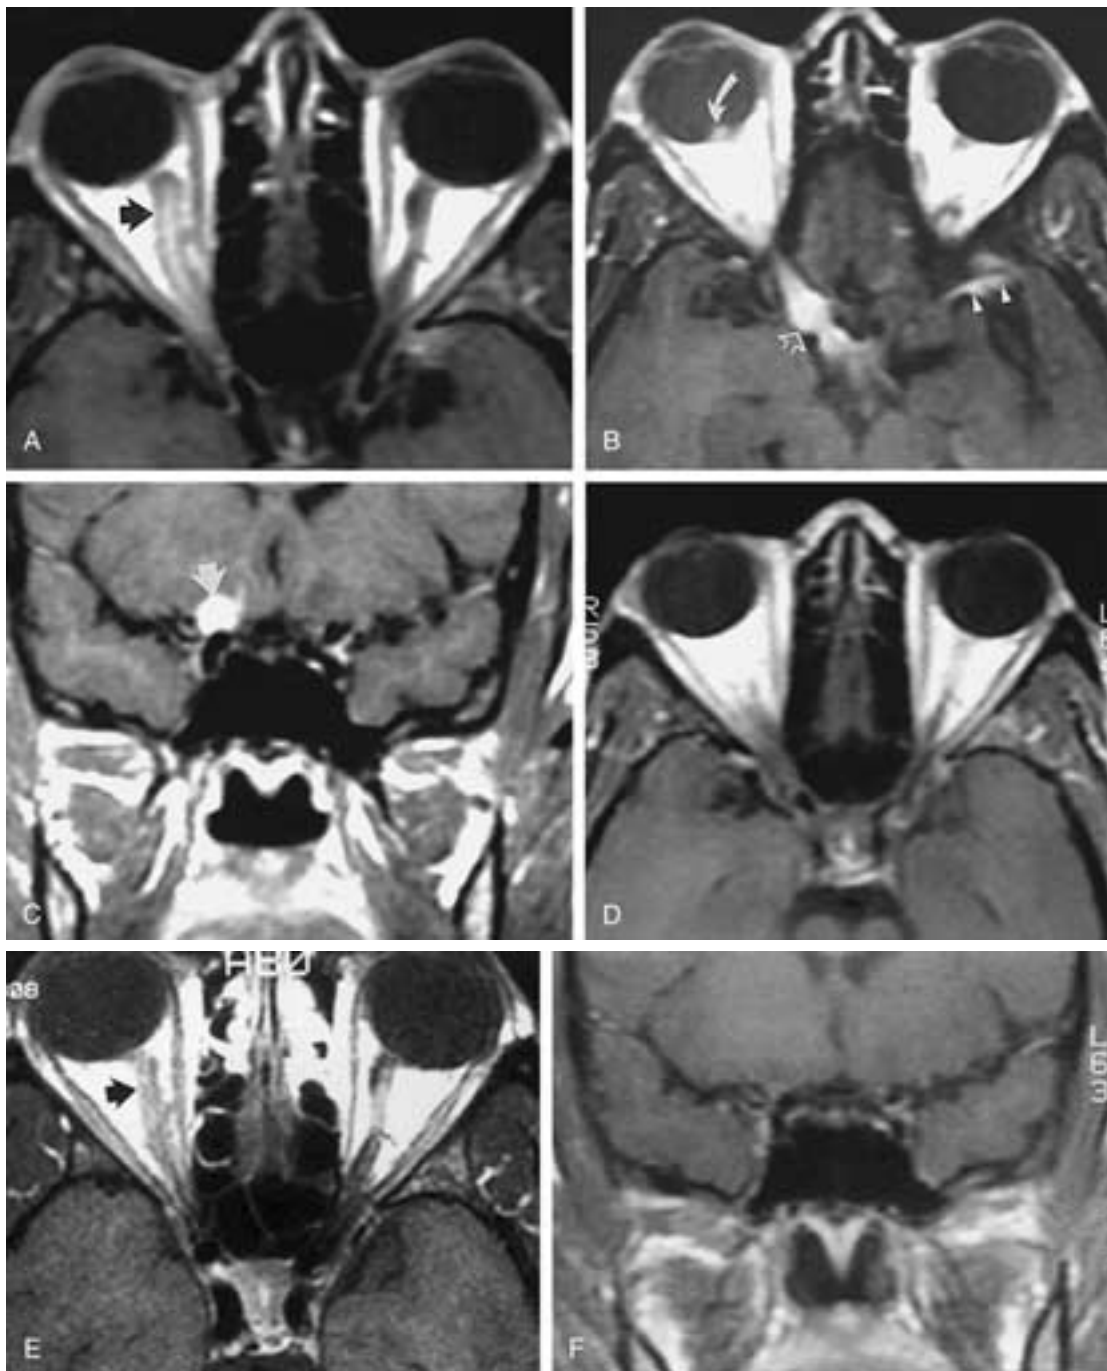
Optic nerve sarcoidosis. A, Enhanced, axial, T1-weighted (600/20, TR/TE) MR image shows increased enhancement of the right optic nerve (*arrow*). B, Enhanced, axial, T1-weighted (600/20, TR/TE) MR scan, taken 3 mm superior to A. Note nodular enhanced lesion (granuloma) involving right globe (*curved arrow*), enhancement of thickened intracranial segment of right optic nerve (*open arrow*), and abnormal enhancement along the anterior left sylvian fissure (*arrowheads*). C, Enhanced, coronal T1-weighted (650/20, TR/TE) MR image shows enlargement as well as marked enhancement of intracranial segment of the right optic nerve (*arrow*). D, Enhanced, axial, T1-weighted (600/20, TR/TE) MR image after corticosteroid treatment. Note absence of abnormal enhancement of the right globe as well as left anterior sylvian fissure (compare with B). E, Enhanced, axial, T1-weighted (612/25, TR/TE) MR image after corticosteroid treatment. Note decreased right optic nerve enhancement (*arrow*). F, Enhanced, coronal, T1-weighted (867/20, TR/TE) MR image. Note absence of enhancement of intracranial segment of right optic nerve, which was seen in C. (From Mafee MF et al. Sarcoidosis of the eye, orbit, and central nervous system. Role of MRI. *Radiol Clin North Am* 1999;37:73–87.)
